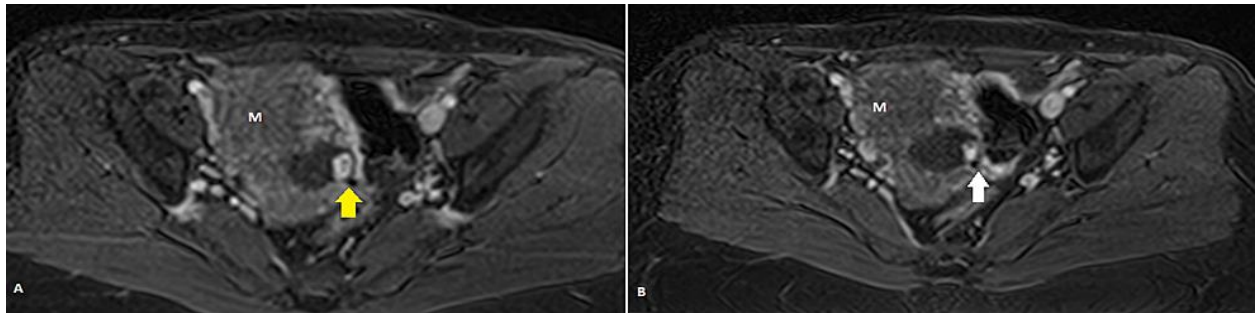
(A and B) Dynamic T1 post-contrast MRI image of a 32-year-old female showing heterogenous uterine parenchyma (M) with abnormal signal in the lower uterine segment (yellow arrow), large vessel (white arrow) reaching up to it with adjacent multiple tortuous uterine vessels.
